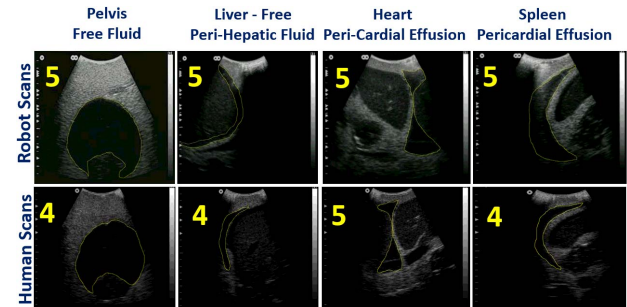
Ultrasound scan comparison with individual image quality scores (1-low, 5-high).
